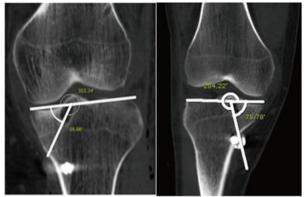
Radiographic measurement of tibial Tunnel
